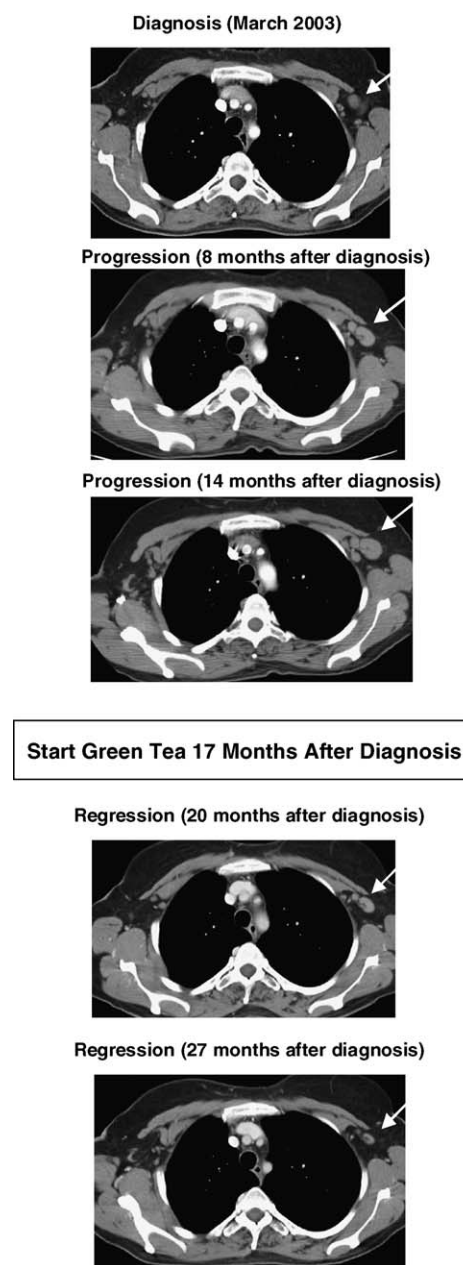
Fifty-five-year-old woman with follicular lymphoma: serial CT scans prior to and after initiation of green tea containing products.
